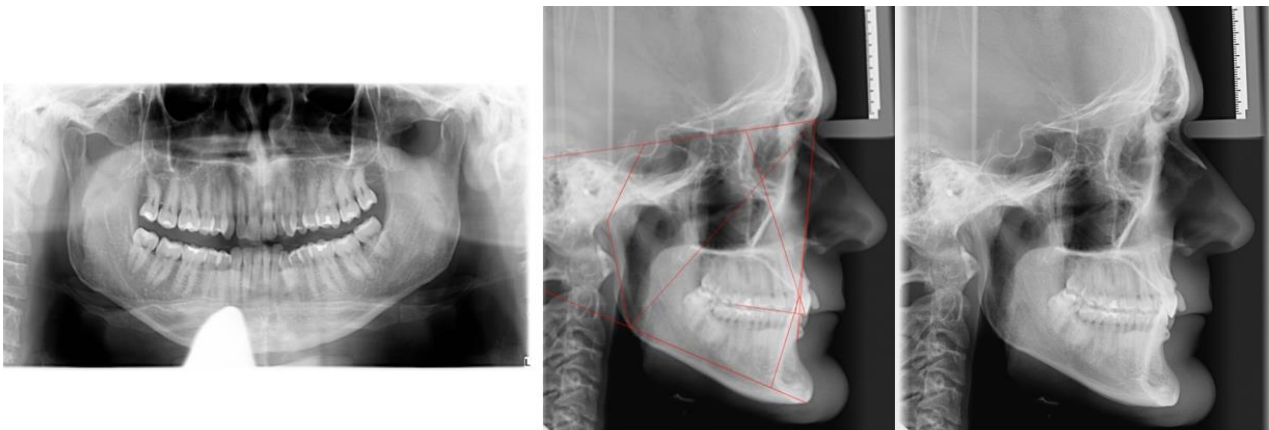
Pre-treatment panoramic radiograph and cephalometric tracing.
